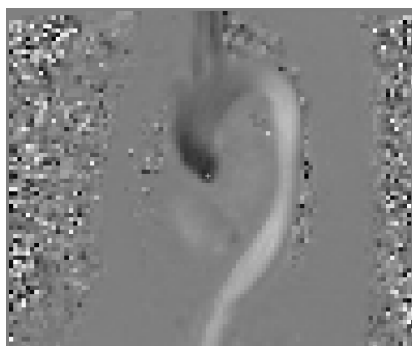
Example of a phase-contrast MR image with velocity encoding in the foot-head direction. In phase-contrast MRI, the pixel intensity in the phase image reflects velocity along the chosen encoding direction, which makes it possible to distinguish flow in different directions.
